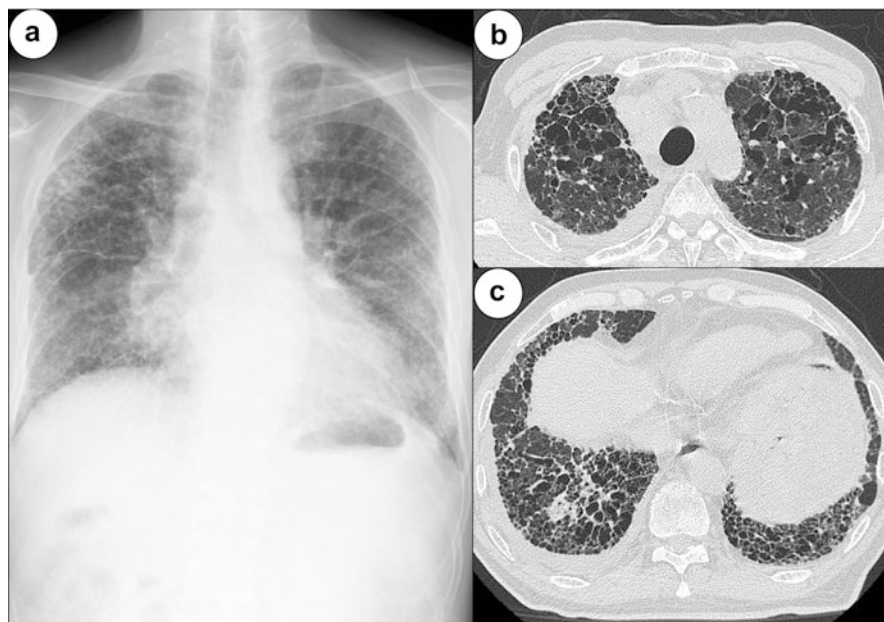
Imaging of a typical case of combined pulmonary fibrosis and emphysema. (a) Chest X-ray showed the emphysema in the upper field and reticular shadow in the lower field. There were tumorlike shadows in the lower right lung field of mediastinum. Despite the existence of marked fibrosis, shrinkage of the lung was seemed to be relatively mild. (b) Chest high resolution computed tomography (HRCT) of the upper zones of the lungs showed paraseptal emphysema in bilateral lungs. (c) Chest HRCT of the lower zones of the lungs showed the typical honeycomb in the bottom, and a lung cancer was complicated in the right lower lobe (S⁹)
